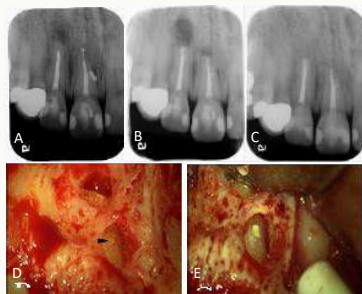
(A) Root canal obturation of tooth #8. (B) Sealer extrusion from lateral canal. (C) Post-operative radiograph. (D) 14-month follow up after surgery. The lateral lesion healed uneventfully. (E) Apical surgery. The black arrow points to a lateral canal opening on the mesio-buccal root surface of tooth #8. (F) MTA retrograde filling in the opening of apex and lateral canal.
